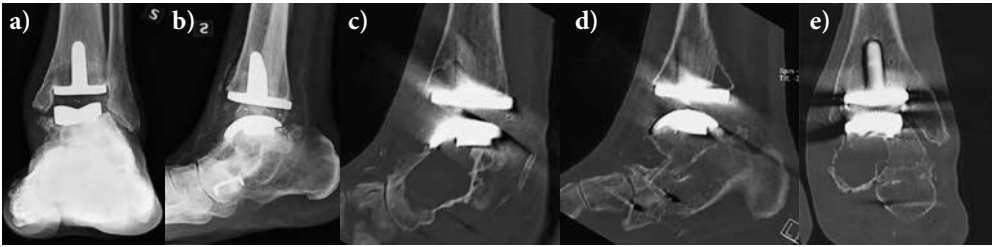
67-year-old male with rheumatoid arthritis. Osteolytic lesions in distal tibia and suspicion of osteolysis also in talus on radiographs 2 years after total ankle replacement (a and b). Several osteolytic lesions in the tibia and one huge lesion with cortical disruption in the talus is seen in CT images 3 years after AES TAR (c-e)
